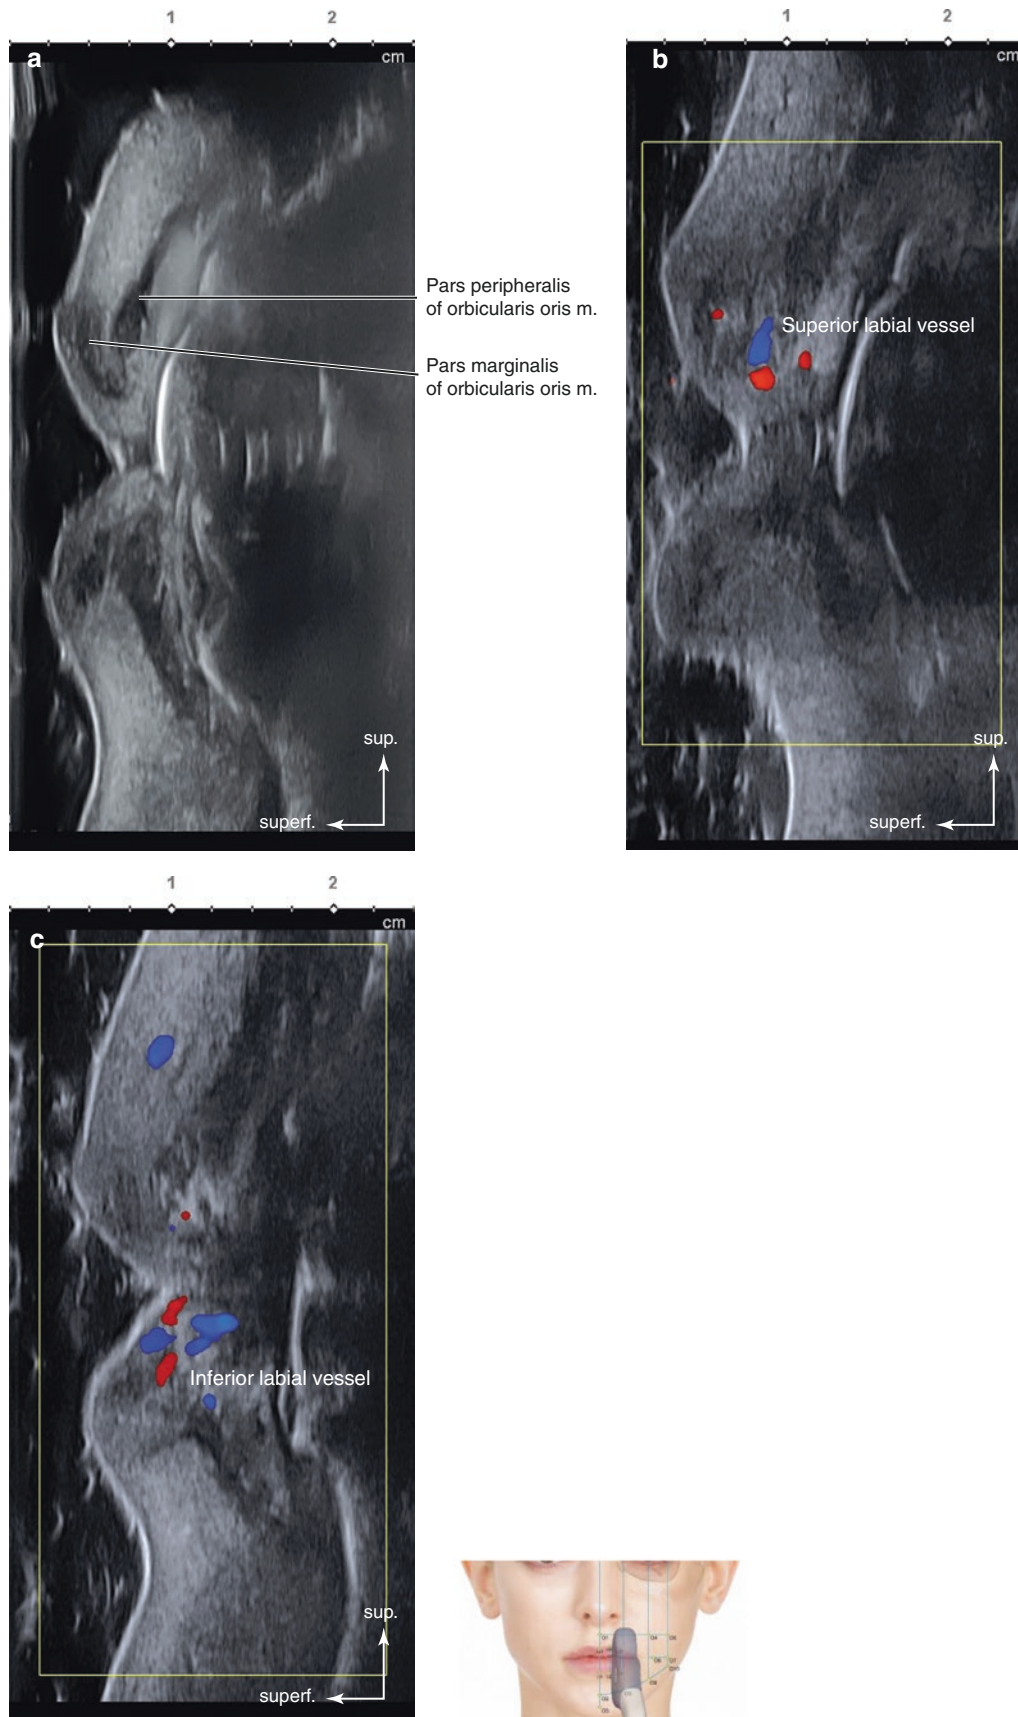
Ultrasonography on the perpendicular line between Ls3 and Li3 (Ls3–Li3). (a) B mode (sagittal view, 15 MHz by linear transducer), (b) Doppler mode (sagittal view, 15 MHz by linear transducer), and (c) Doppler mode (sagittal view, 15 MHz by linear transducer). (Published with kind permission of © Hee-Jin Kim 2020. All Rights Reserved)
